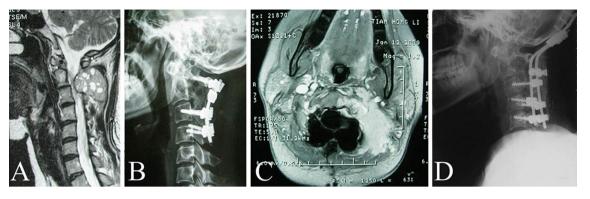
Radiologic images of a patients with SMGCT (case, #5). a MRI image in June 2008 revealed a osteolytic lesion in vertebral body and the accessories of C2 (benign GCT). b Postoperative lateral radiograph in June 2008 showed the reconstruction performed from
